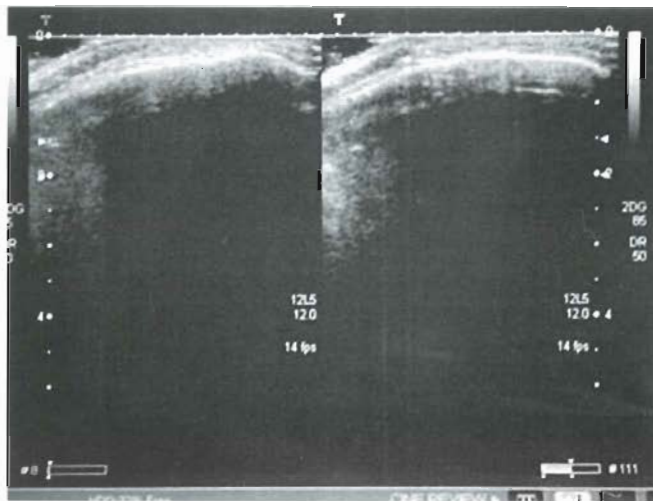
Ultrasonography follow-up 12 months after surgery (completed resorption).
